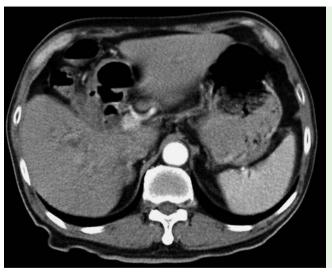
Computed tomography (CT) scan showing the hypodensity tract which connected gallbladder and duodenum.
